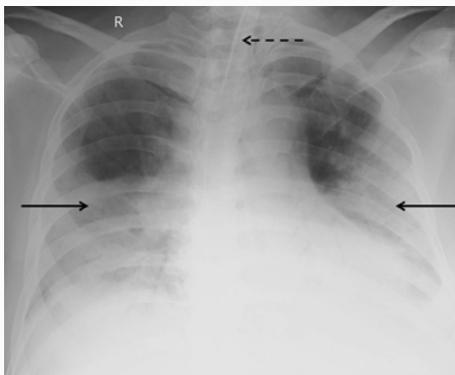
AP chest radiograph of 54-year-old male showing consolidation involving bilateral mid and lower zones (black arrows). Note the endotracheal tube *in situ* (dashed arrow).
